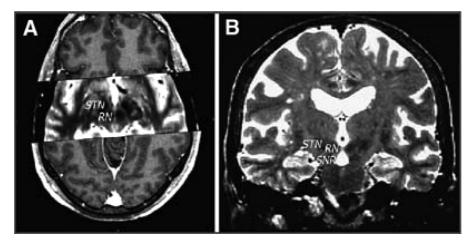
STN on MRI high resolution axial (A) and coronal (B) T2-weighted MRI scans. Anatomical location of STN is anterosuperolateral to substantia nigra pars reticulate (SNR) and red nucleus (RN). (Reprinted with permission from Rezai *et al.* [16].)
